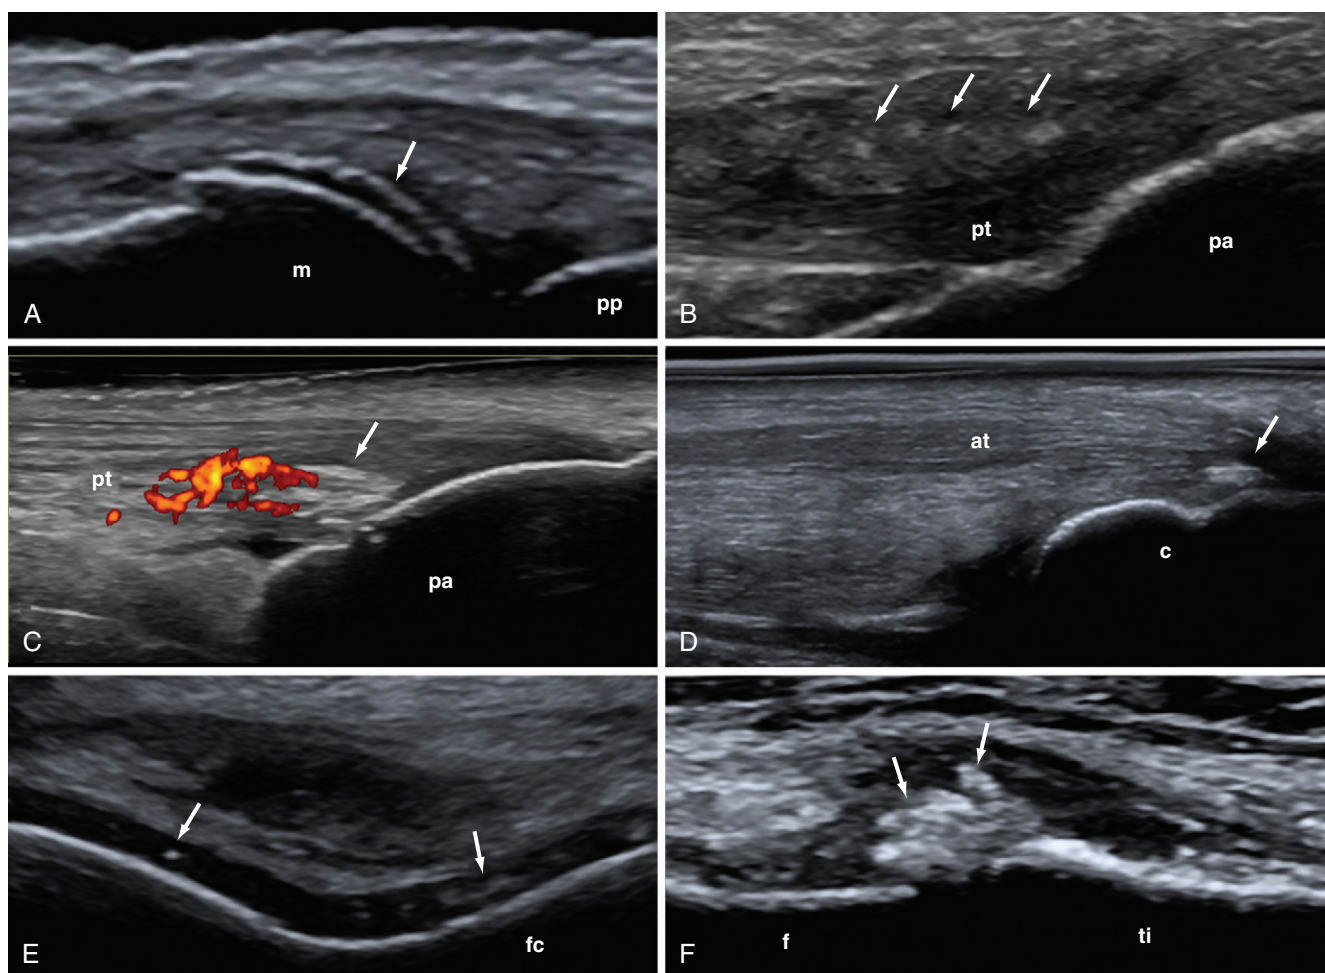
Gout and calcium pyrophosphate dihydrate (CPPD) crystal deposition disease (ultrasonography). A through C, Gout. A, Chronic gout. Metacarpophalangeal joint (longitudinal scan with fingers in full flexion): hyperechoic enhancement of the chondrosynovial interface (*arrow*) due to monosodium urate crystal deposition. B, Distal patellar enthesis (longitudinal anterior scan): intratendinous monosodium urate deposits (*arrows*). C, Distal patellar enthesis (longitudinal anterior scan): tophaceous deposits (*arrow*) surrounded by power Doppler signal. D through F, CPPD crystal deposition disease. D, Achilles tendon (at) (longitudinal scan): intratendinous linear hyperechoic deposits without acoustic shadow (*arrow*). E, Femoral hyaline cartilage (transverse scan): calcium pyrophosphate deposits within the hyaline cartilage (*arrows*). F, Knee (longitudinal lateral scan): diffuse meniscal calcification (*arrows*). c, calcaneus; f, femur; fc, femoral condyle; m, metacarpal head; pa, patella; pp, proximal phalanx; pt, patellar tendon; ti, tibia.
